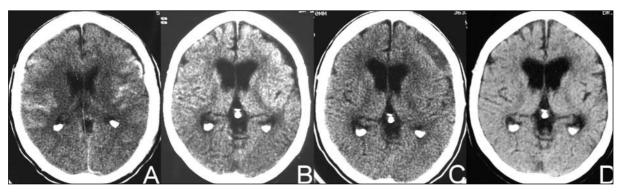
Case 3. (A) CT scan on admission showing diffuse subarachnoid hemorrhage and small subdural effusion in the left frontal region (1st day). (B) CT scan showing subdural hygroma with probable compression on the underlying brain (4th day). (C) CT scan showing enhanced density and increased volume, with probable ipsolateral compression on the underlying brain (77th day). (D) CT scan showing disappearance of the subdural collection (2 years later).
